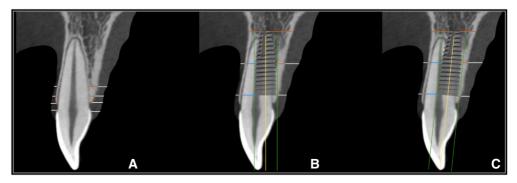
Sagittal radiographic sections demonstrate method followed to assess dimensions of buccal and palatal bone (*orange line*) and soft tissue (*white line*) at different apico-coronal landmarks. Buccal and palatal bone (*orange line*) and soft tissue thickness (*white lines*) at different apico-coronal landmarks, and buccal gap distance (*blue line*) at most coronal and middle regions of implant. A, At baseline. B, When implant placed according to cingulum emergence plan. C. When implant placed according to incisal edge emergence plan.
